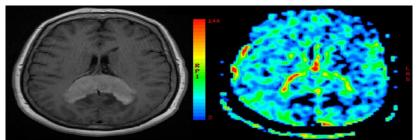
Same patient as in figure 9. Enhanced T1-WI MRI demonstrates a homogeneously enhancing mass in the splenium of the corpus callosum. Perfusion MR imaging shows a relative low perfusion within the contrast-enhancing tumor on the rCBV map, which indicates no significant localized neoangiogenesis.
